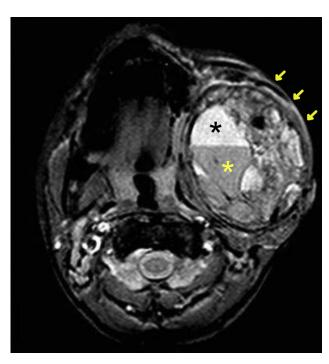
Axial T2-weighted magnetic resonance image showing an ABC at the left angle of the mandible (arrows) with fluid-fluid levels (asterisks).
